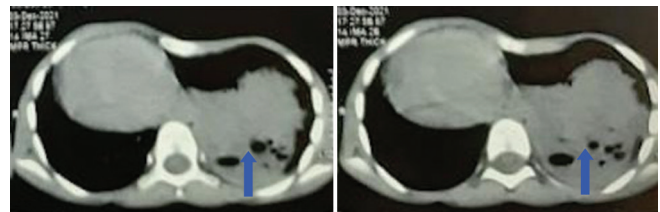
Computed tomography scan thorax revealed a heterogeneous well-defined lesion 7.6 cm × 7.2 cm × 5.3 cm heterogeneous well-defined lesion with multiple cystic lesions in the posterior part of the left lower lobe (Blue Arrow)
